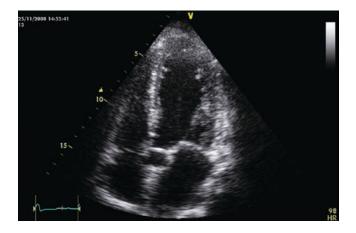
Apical two-chamber view
